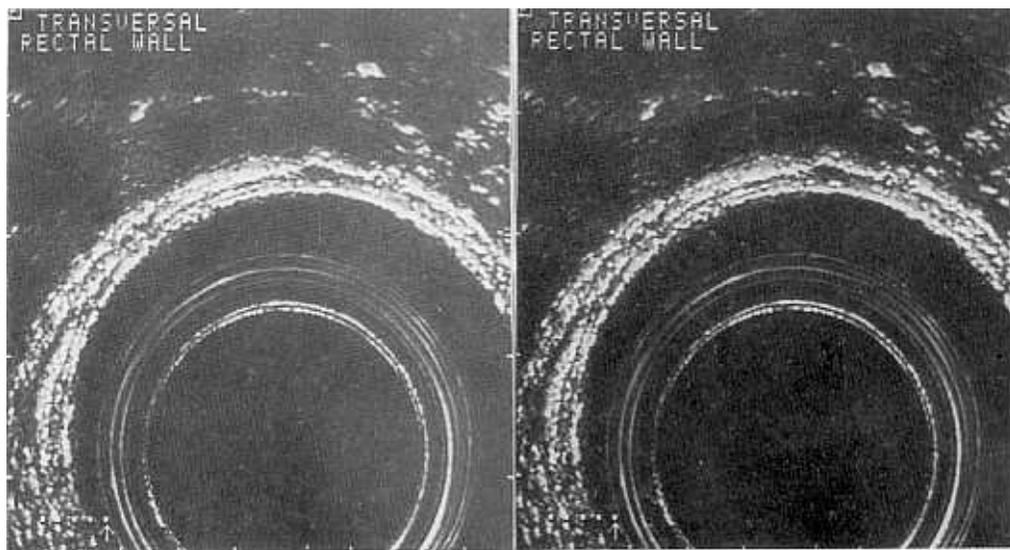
Normal rectal wall. The five lines (three hyperechoic, white, and two hypoechoic, black) are clearly discernible in the ultrasonographic image of the rectal wall.
